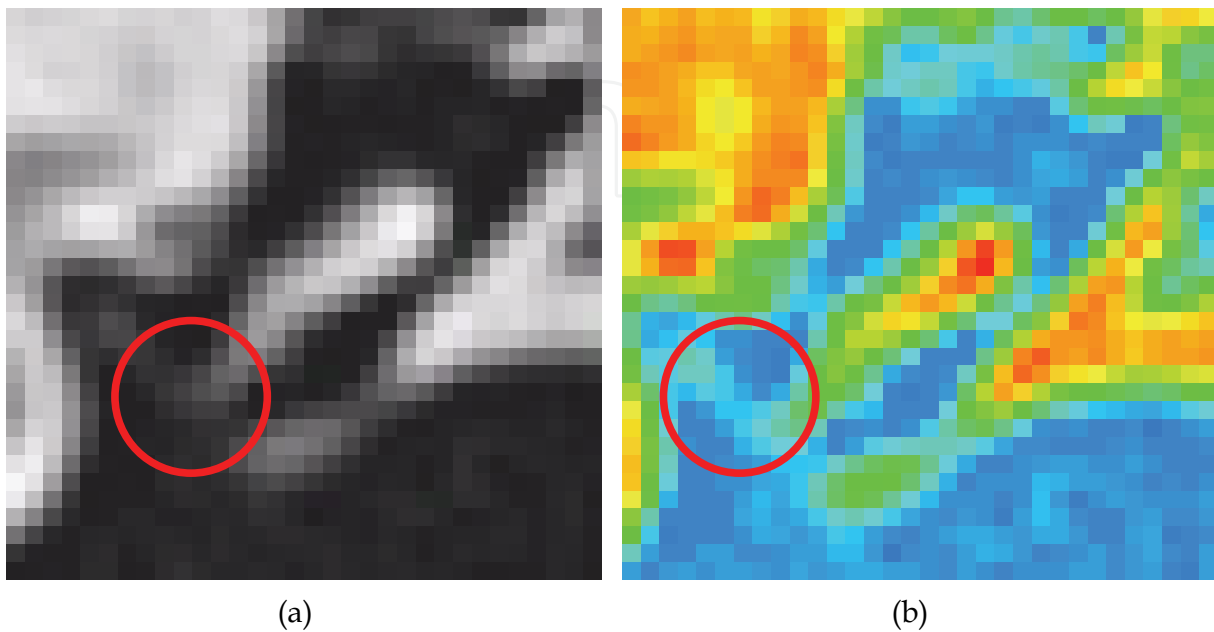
Coronal image of CT showing pseudocolor transformation of incudostapedial joint. a) plain image. b) pseudocolor transformed image (red to blue). Red circles indicate incudostapedial joint.
